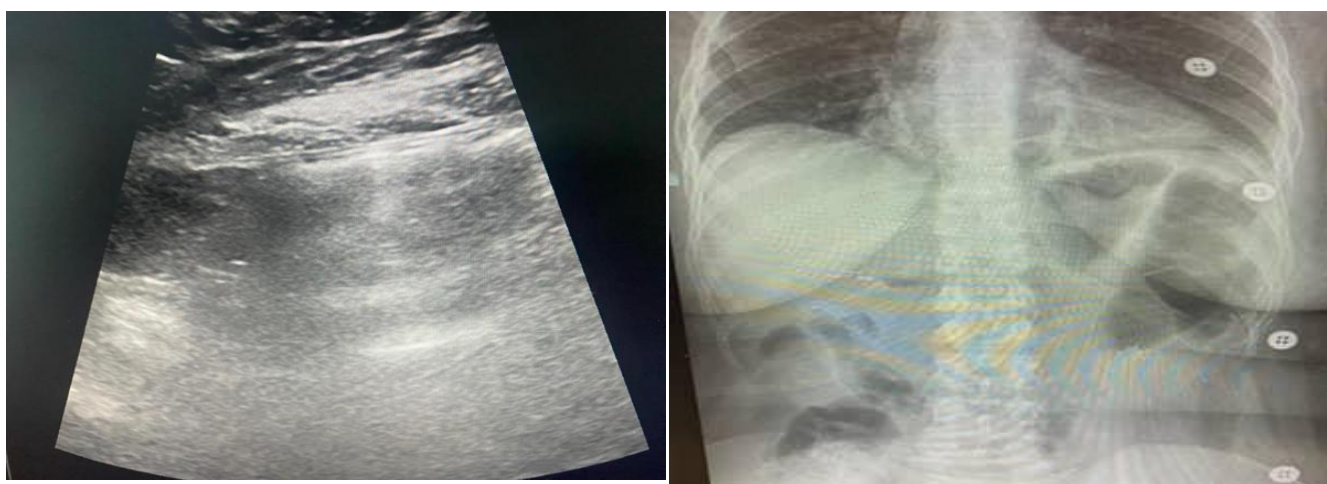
Comparison of Ultrasound and X-ray Images of post-surgical pneumoperitoneum of the same patient
